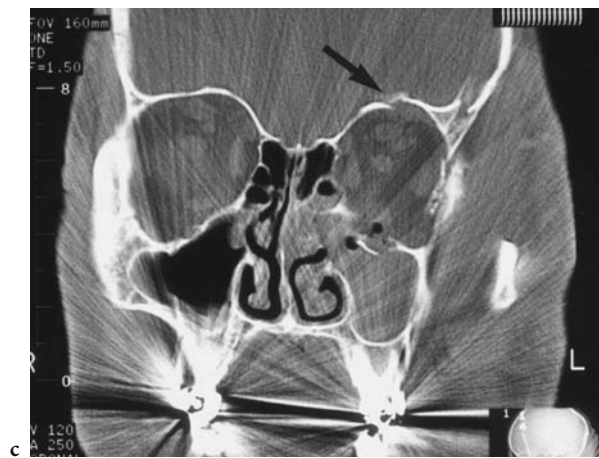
A 52-year-old man presenting with a swollen lid after a sudden fall; indication for CT was the exclusion of a retrobulbar hematoma. Diagnosis: fracture of all orbital walls, small superior subperiosteal hematoma. CT: a Axial view with extensive swelling of the lid and conjunctiva, no retrobulbar hematoma, irregularity of the lateral orbital wall at the spheno-zygomatic suture. b Corresponding bone window clearly demonstrating the dislocated, fragmented fracture. c Coronal view (bone window) showing fractures of all orbital walls (lateral, floor, lamina papyracea, and roof), and a small subperiosteal hematoma at the orbital roof (*arrow*)
